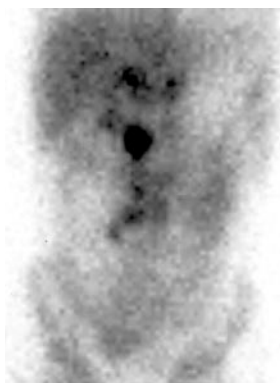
Gallium scintigraphy in Patient 1 shows an abnormal accumulation of the nuclide in the para-aortic lymph nodes.
